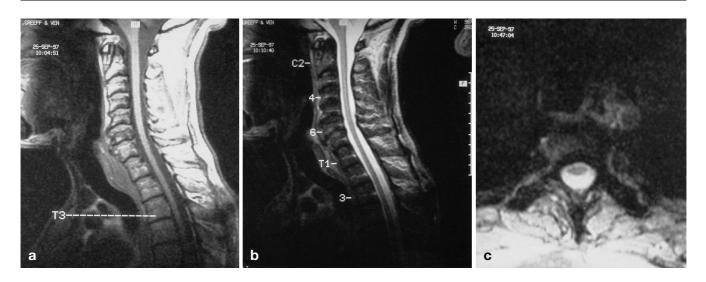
Case 2. MRI showing mild atrophy of the thoracic spinal cord. a T1-weighted b proton density and T2-weighted sagittal image. c T2-weighted axial spin-echo image at T3
